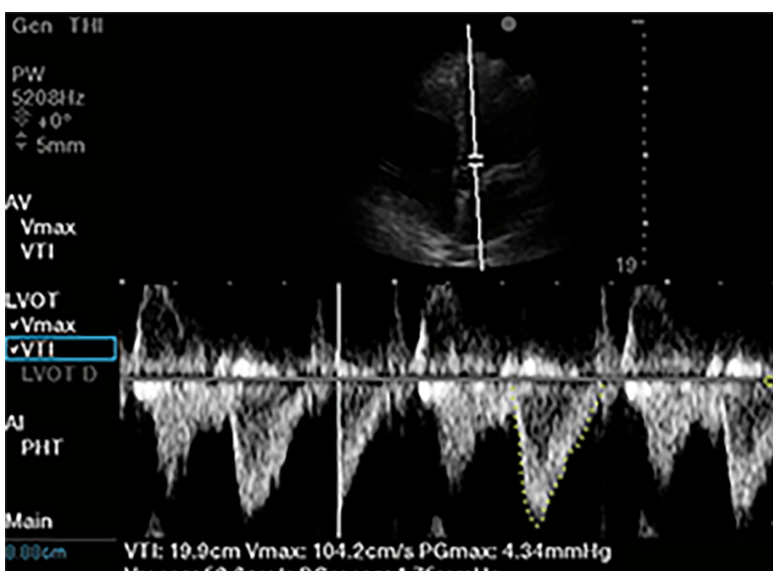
Left ventricular outflow tract velocity time integral. Of 1-5 MHz phased array probe, apical 5 chamber view. Pulsed wave doppler selected, with sample volume placed 5 mm proximal to aortic valve in center of the left ventricular outflow tract. Notice narrow signal with rapid upstroke in velocities, with end-systolic click terminating flow signal. In this case traced velocity time integral was 19.9 cm.
